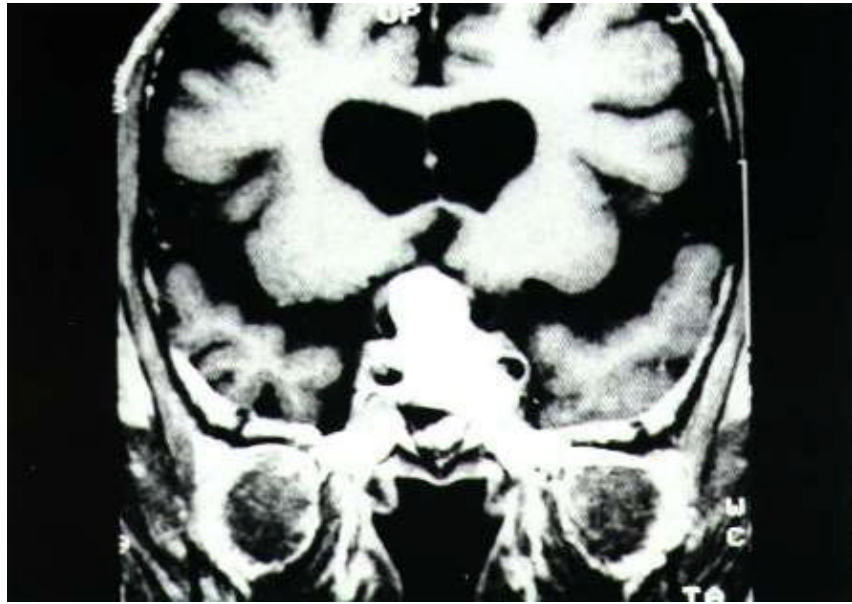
MRI image (coronal view) of case 1.
